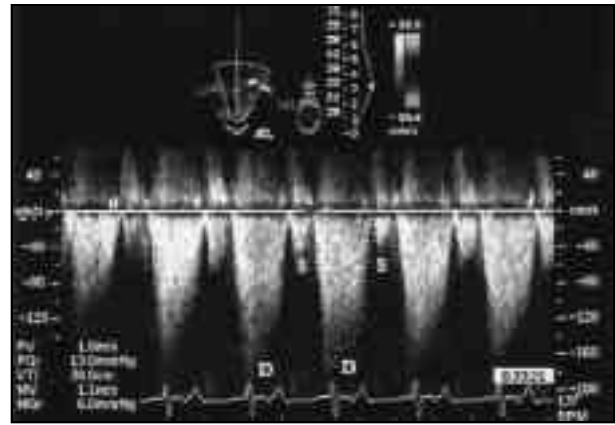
(B) Spectral Doppler flow wave showed high peak diastolic and systolic velocities, which did not change with intravenous injection of nitroglycerine.
